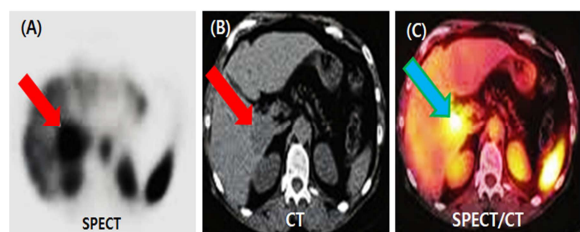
Hepatic Hemangioma.(A) SPECT image, (B) CT image, (c) SPECT/CT image
